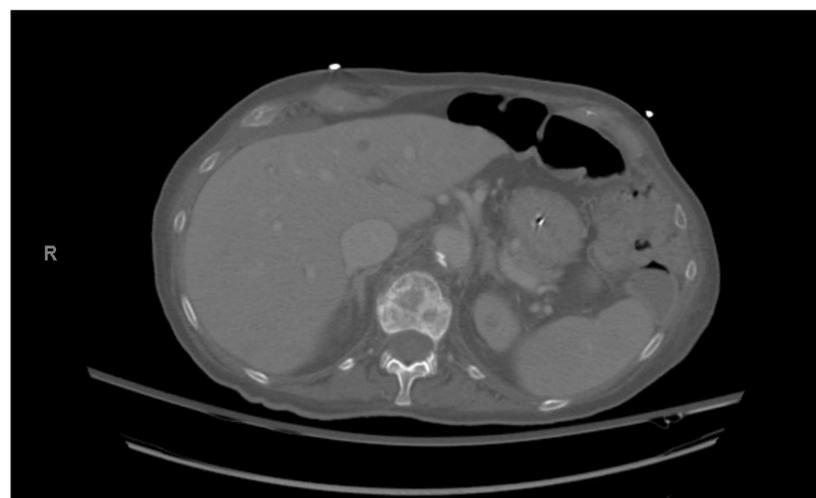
Patient's CT Abdomen Pelvis showing a normal liver morphology.
